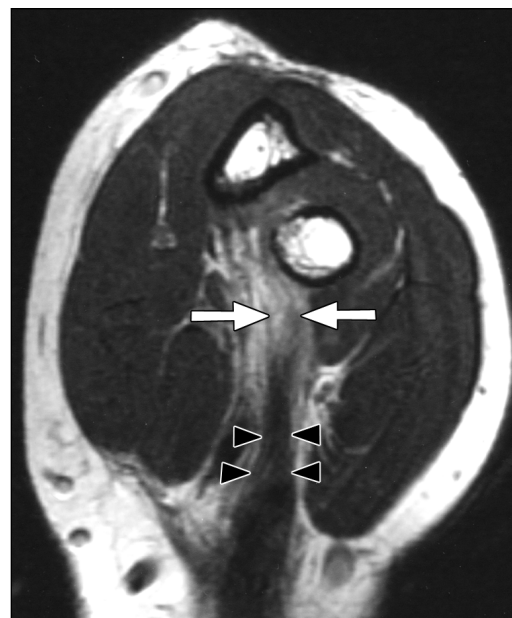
49-year-old man with complete tear of left distal biceps brachii tendon. Proton density-weighted MR image (TR/TE, 3,000/34) of flexed abducted supinated view of complete tendon tear shows discontinuity of tendon and abnormally thickened proximal part of tendon. Arrows = gap as result of complete tear, arrowheads = thickened remaining distal biceps brachii tendon.
